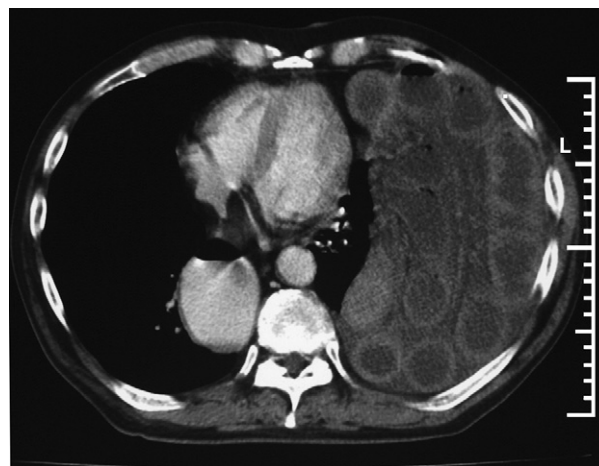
Computed tomographic scan of the thorax.
